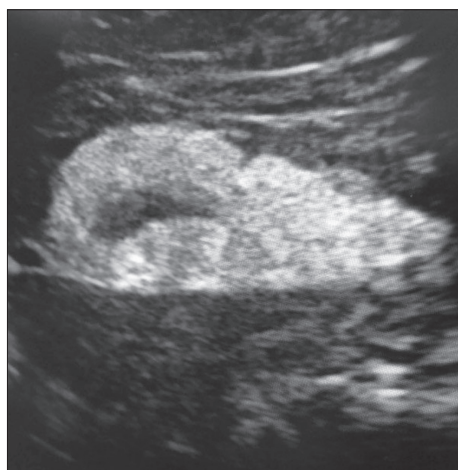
The intraoperative ultrasound view of liver angiomyolipoma
